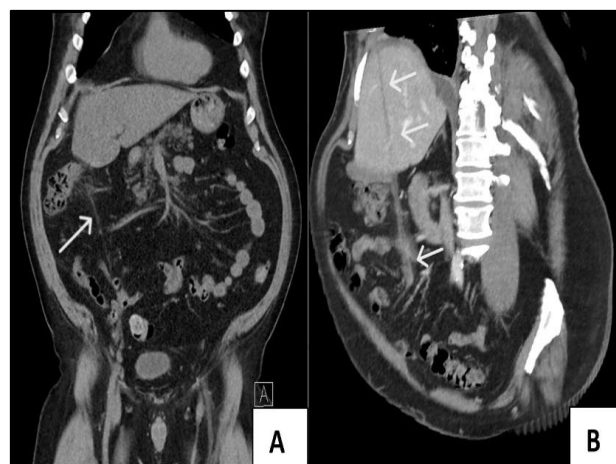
(A) Coronal contrast enhanced CT image showing the plastic ligature tube sheath migrating in a cranial fashion; the white arrow indicates the ligature tube sheath lying in an oblique angle; (B) Multiplanar reformation coronal CT image of the ligature tube sheath migrating through the liver in a complete penetrating injury; the pointed sharp end of the sheath has erupted through liver capsule and into the right diaphragm.
